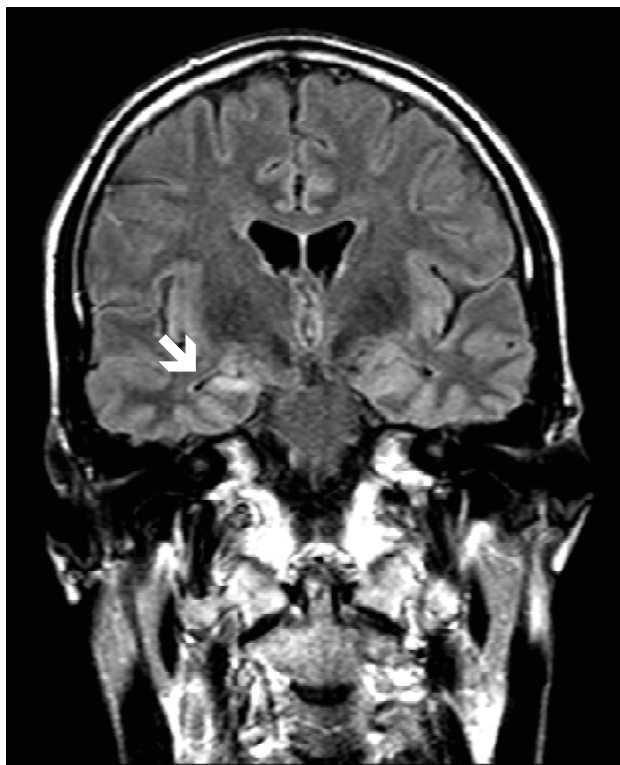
Magnetic resonance imaging (FLAIR sequence) of a patient with right hippocampus sclerosis
